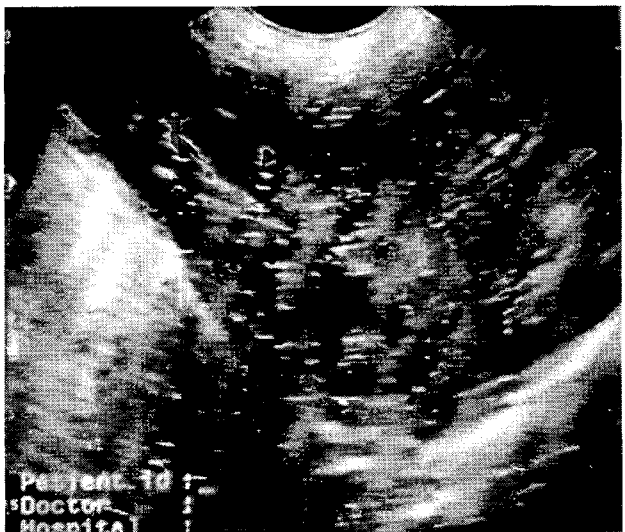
Pelvic dilatation and partial echogenicity with enlarged and irregular architecture in ultrasonography.
